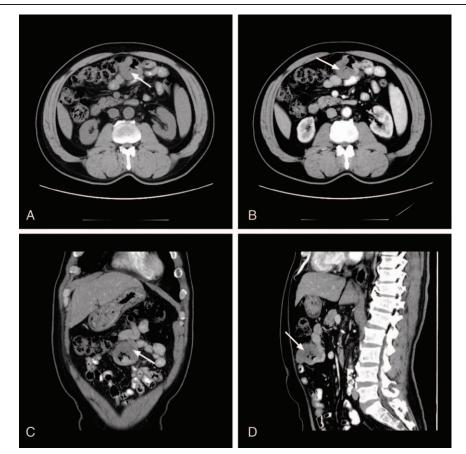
Abdominal contrast-enhanced computed tomography (CT) revealed a small intestine mass in the middle abdomen. (A) Axial imagine of the mass without CT contrast medium. (B) Axial imagine by contrast-enhanced CT. (C and D) Coronal and sagittal plane CT images of the tumor mass. CT = computed tomography.
